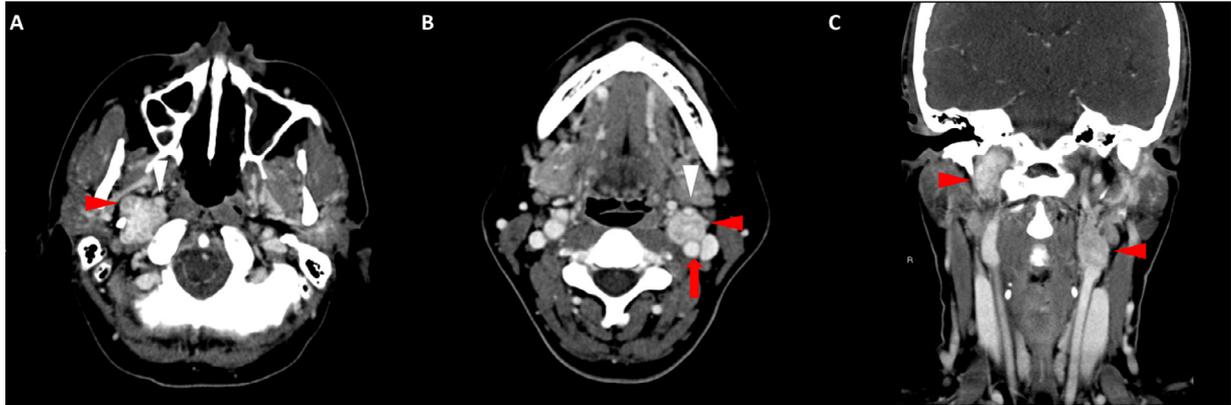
Right vagal and left carotid body paragangliomas. (A) Axial contrast-enhanced CT in the axial plane demonstrates an avidly enhancing mass (red arrowhead) in the right carotid space, posterior to the right internal carotid artery (white arrowhead) and medial to the styloid process. (B) Axial contrast-enhanced CT demonstrates an avidly enhancing mass (red arrowhead) in the left carotid space, which splays the internal carotid artery posteriorly (red arrow), and the external carotid artery anteriorly (red arrow). (C) Coronal contrast-enhanced CT shows both enhancing masses (red arrowheads). (Color version of figure is available online.)
